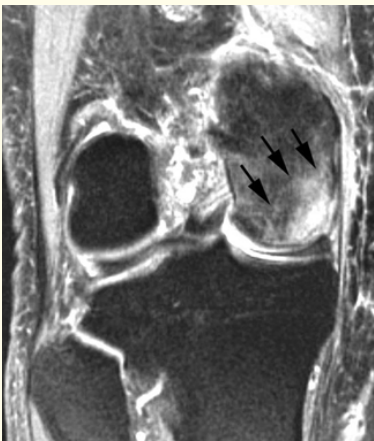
This MRI scan shows osteonecrosis in the medial femoral condyle. An MRI is often used to detect early.
